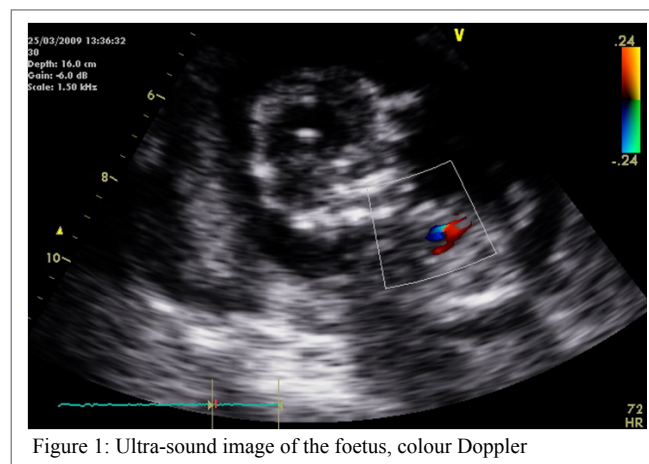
Ultra-sound image of the foetus, colour Doppler
